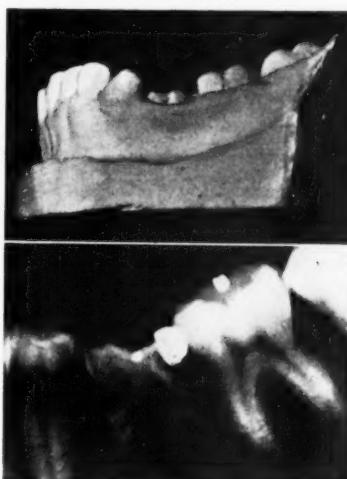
Radiograph of patient referred to in figure 1. In this case the second bicuspid is congenitally absent.
